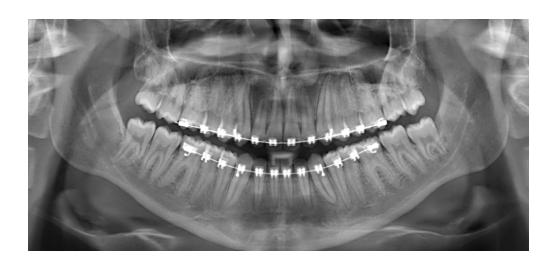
Panoramic control X-ray
